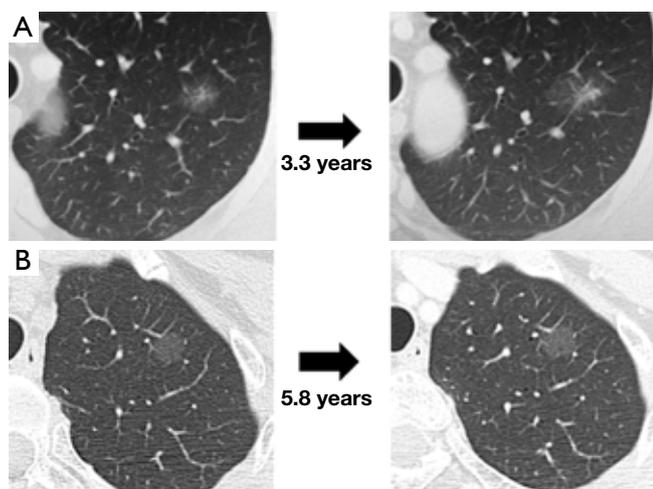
Computed tomography images of two representative pulmonary nodules with GGOs. A, A part-solid GGO lesion became larger, and its solid component increased after 3.3 years. B, A pure GGO lesion persisted without changing in size for 5.8 years.
